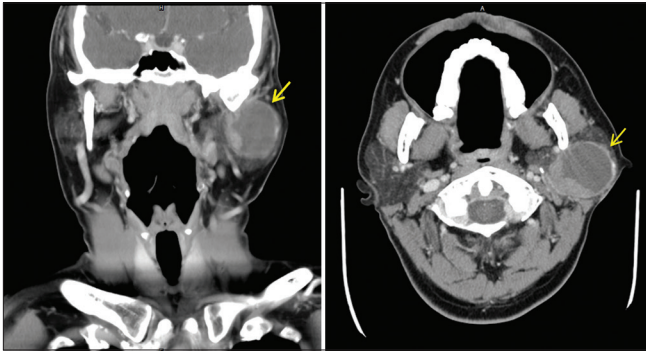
Computed tomography scan of head and neck showing a 4.1 cm cystic mass (arrow) with irregular wall thickening at the left parotid gland
